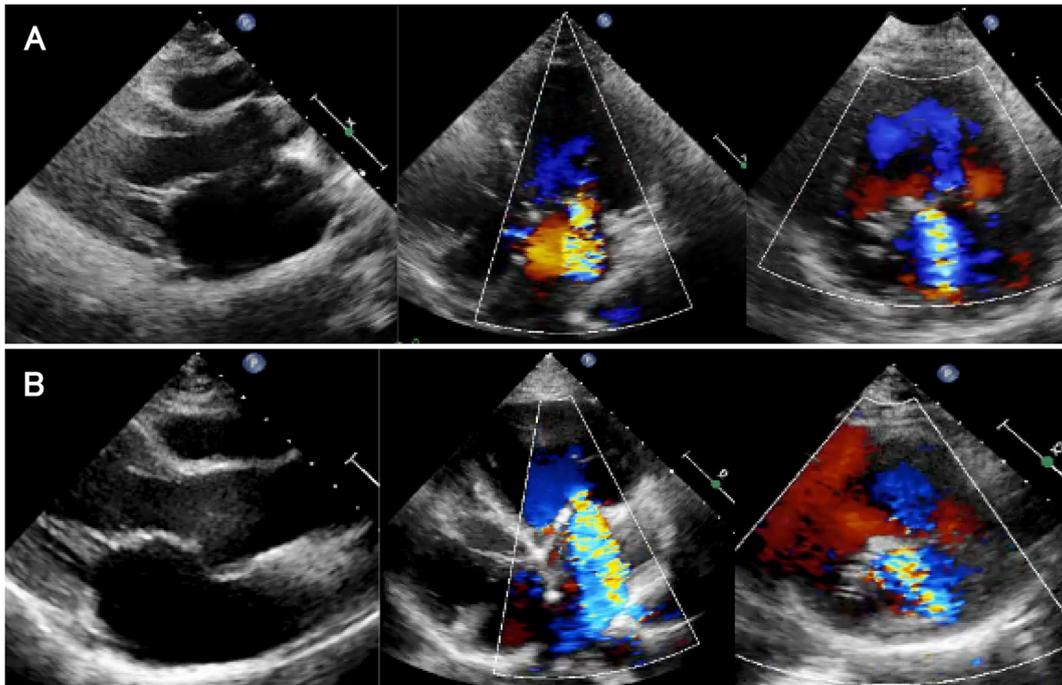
Echocardiograms (A) during the third trimester of the first pregnancy and (B) during the second trimester of the second pregnancy. Each view shows exacerbation of left atrial dilatation and left atrioventricular valve regurgitation during the second pregnancy compared to the first pregnancy. (Left: parasternal long axis view. Middle: apical four chamber view. Right: short axis view at level of the atrioventricular valve.)
